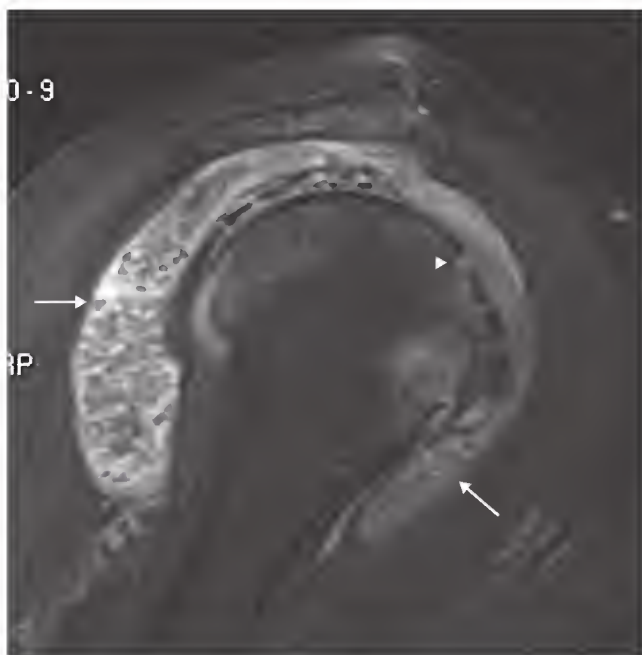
Sagittal fat-saturated proton density-weighted magnetic resonance image of the shoulder demonstrating large chronic subacromial or subdeltoid bursal fluid inflammation and rice body formation (arrows). Erosion (arrowhead) is present in the humeral head.
